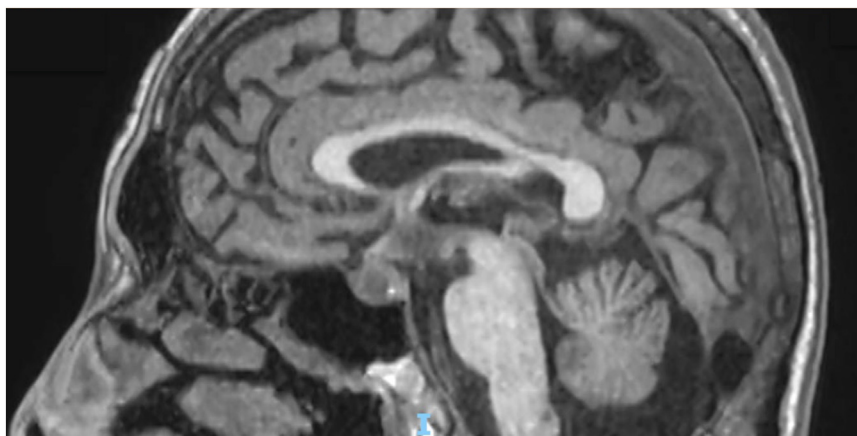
Brain magnetic resonance imaging showing a heterogeneous pituitary gland of probable infectious/inflammatory etiology due to the presence of an 8×8 mm abscess.
